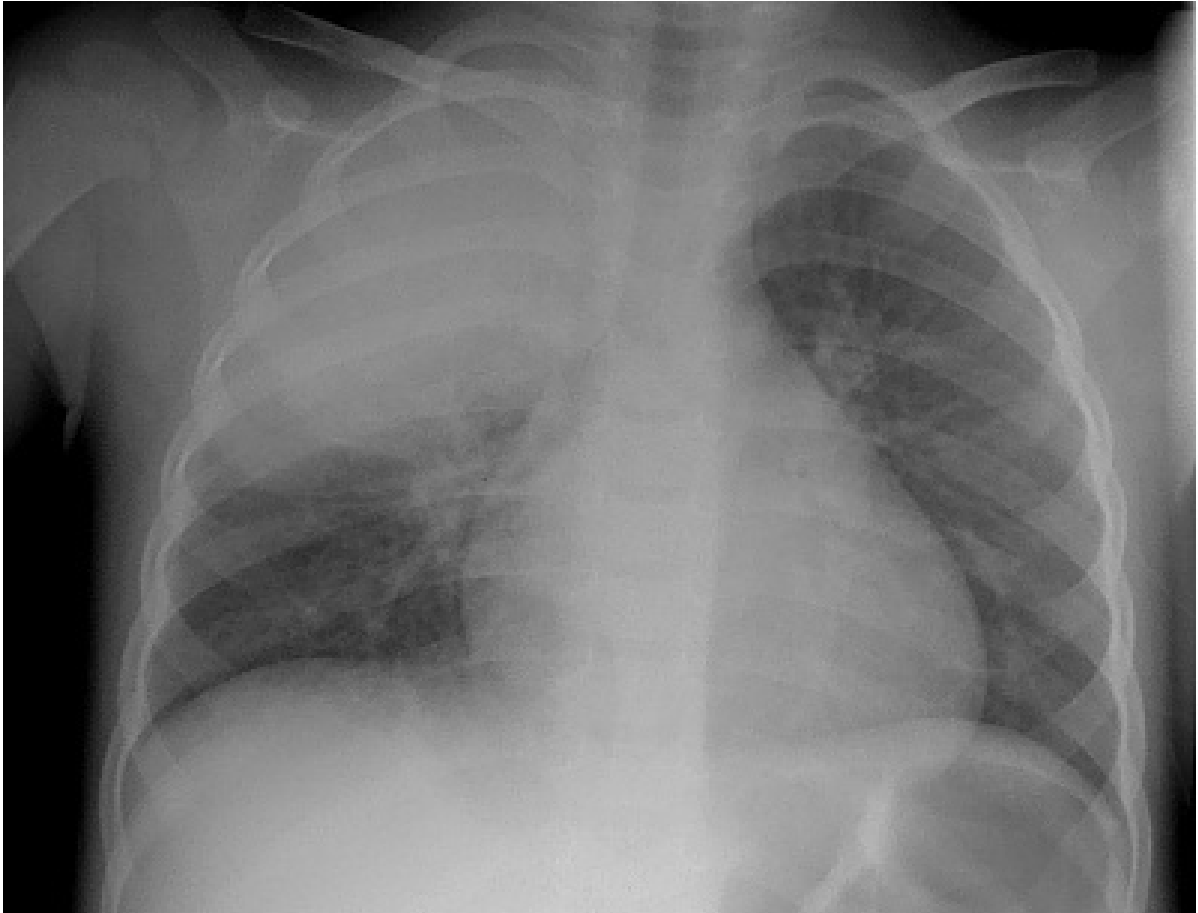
What are the changes on the radiograph?
